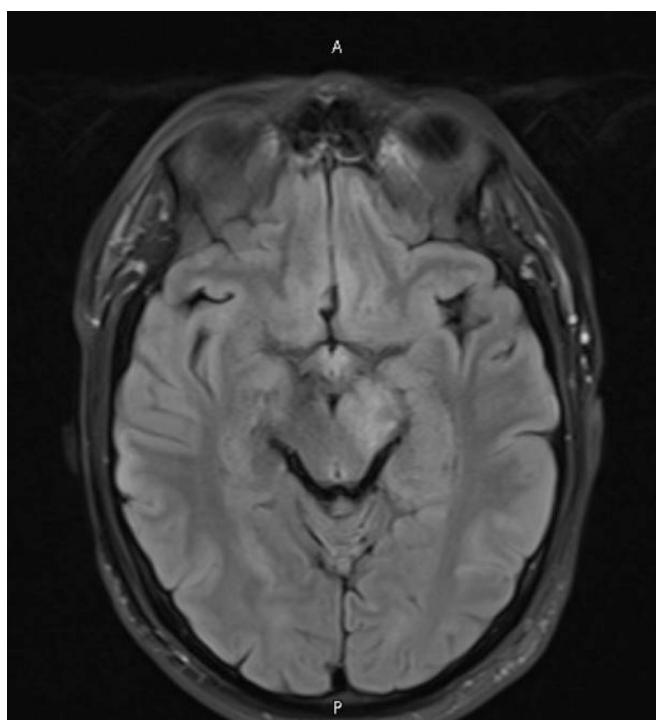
Focal T2/FLAIR hyperintensity is seen in the left midbrain.
